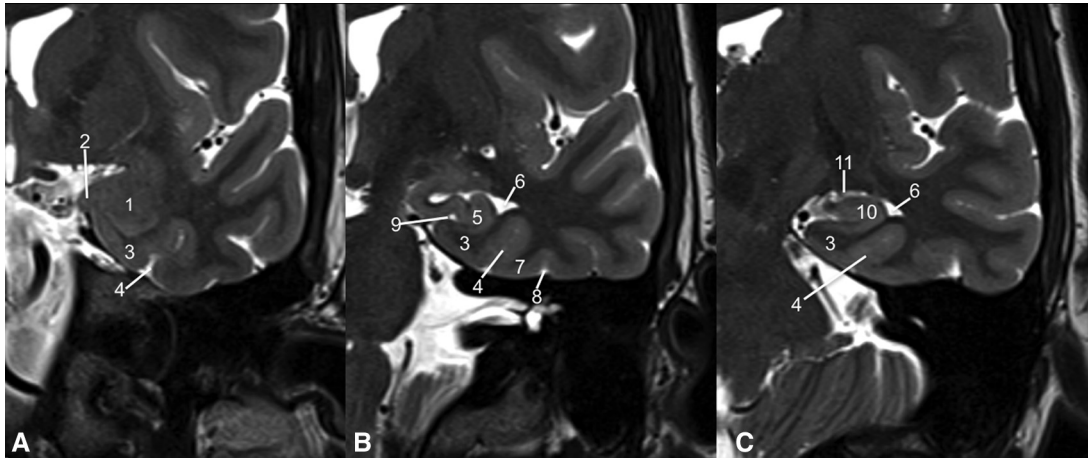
Normal radiological anatomy of the mesial temporal lobe. Coronal T2-weighted magnetic resonance image at (A) amygdala, (B) hippocampal head and (C) hippocampal body sections. 1. Amygdala, 2. uncus, 3. parahippocampal gyrus, 4. collateral sulcus, 5. hippocampal head, 6. temporal horn of lateral ventricle, 7. fusiform gyrus, 8. temporo-occipital sulcus, 9. hippocampal fissure, 10. hippocampal body, 11. choroid fissure.
